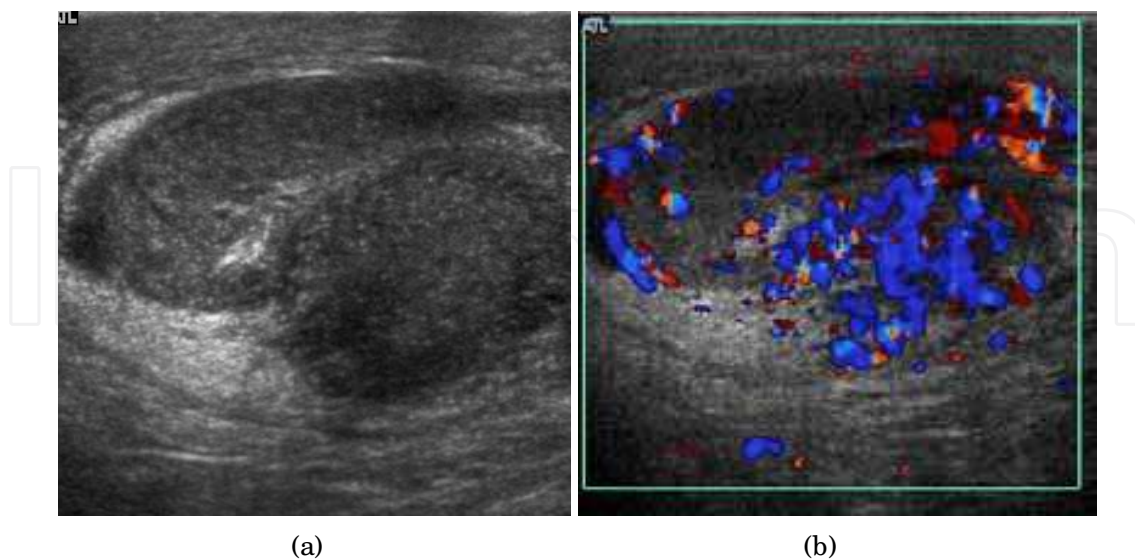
Epididymo-orchitis in a 77 year-old man. (a) Transverse sonography shows enlargement of the epididymis with hypoechogenicity noted over the testis and epididymis associated with scrotal wall thickening. (b) Color Doppler sonography showed hyperemic change of the testis and epididymis, presenting as an “inferno” vascular flow pattern
